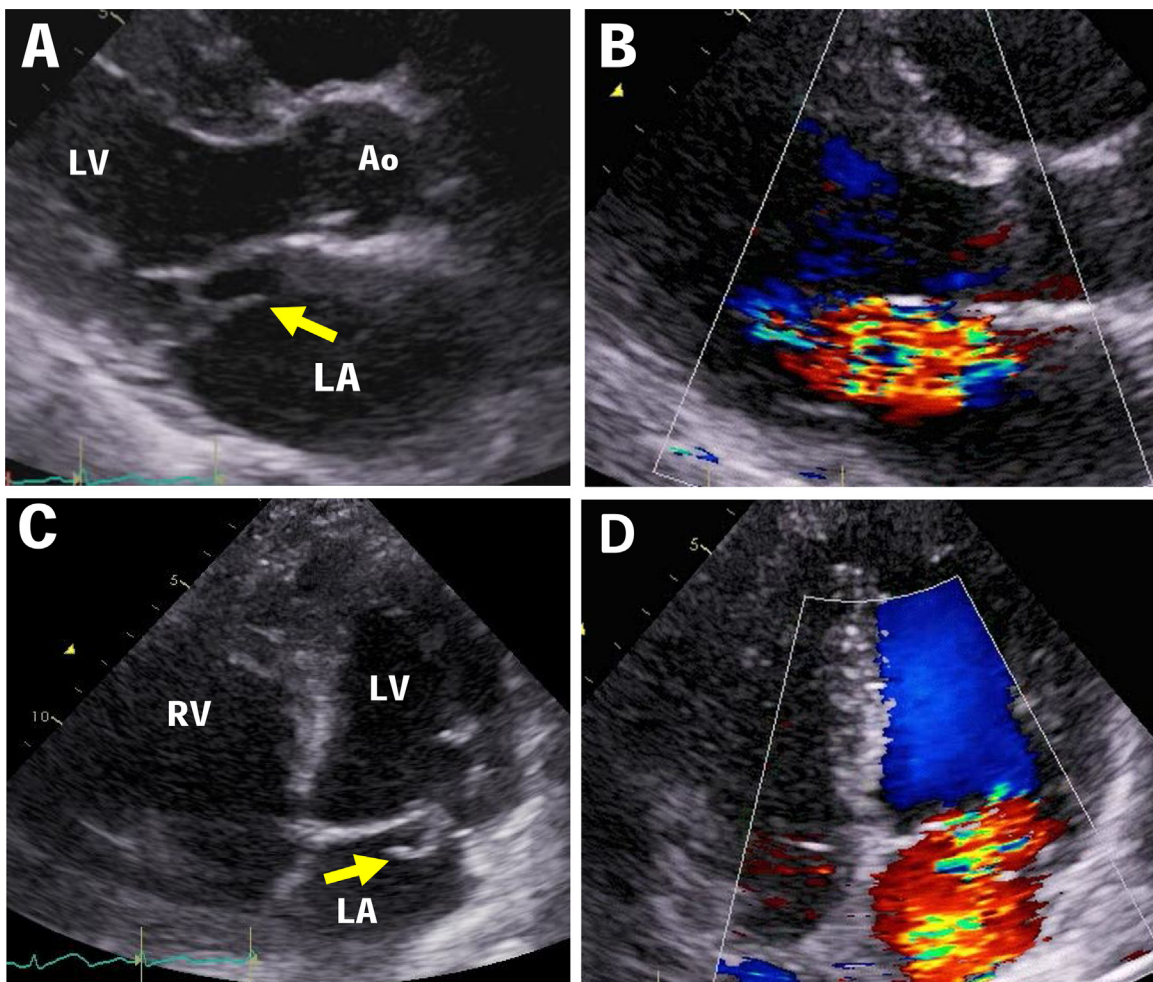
Transthoracic echocardiograms in the long-axis view (upper panel) and apical four-chamber view (lower panel). Chordal rupture of the posterior mitral valve P₂ leaflet is shown (A,C: arrow). Severe mitral regurgitation was first directed anterolaterally and then to the right side of the LA (B,D). Ao, aorta; LA, left atrium; LV, left ventricle; RV, right ventricle.
